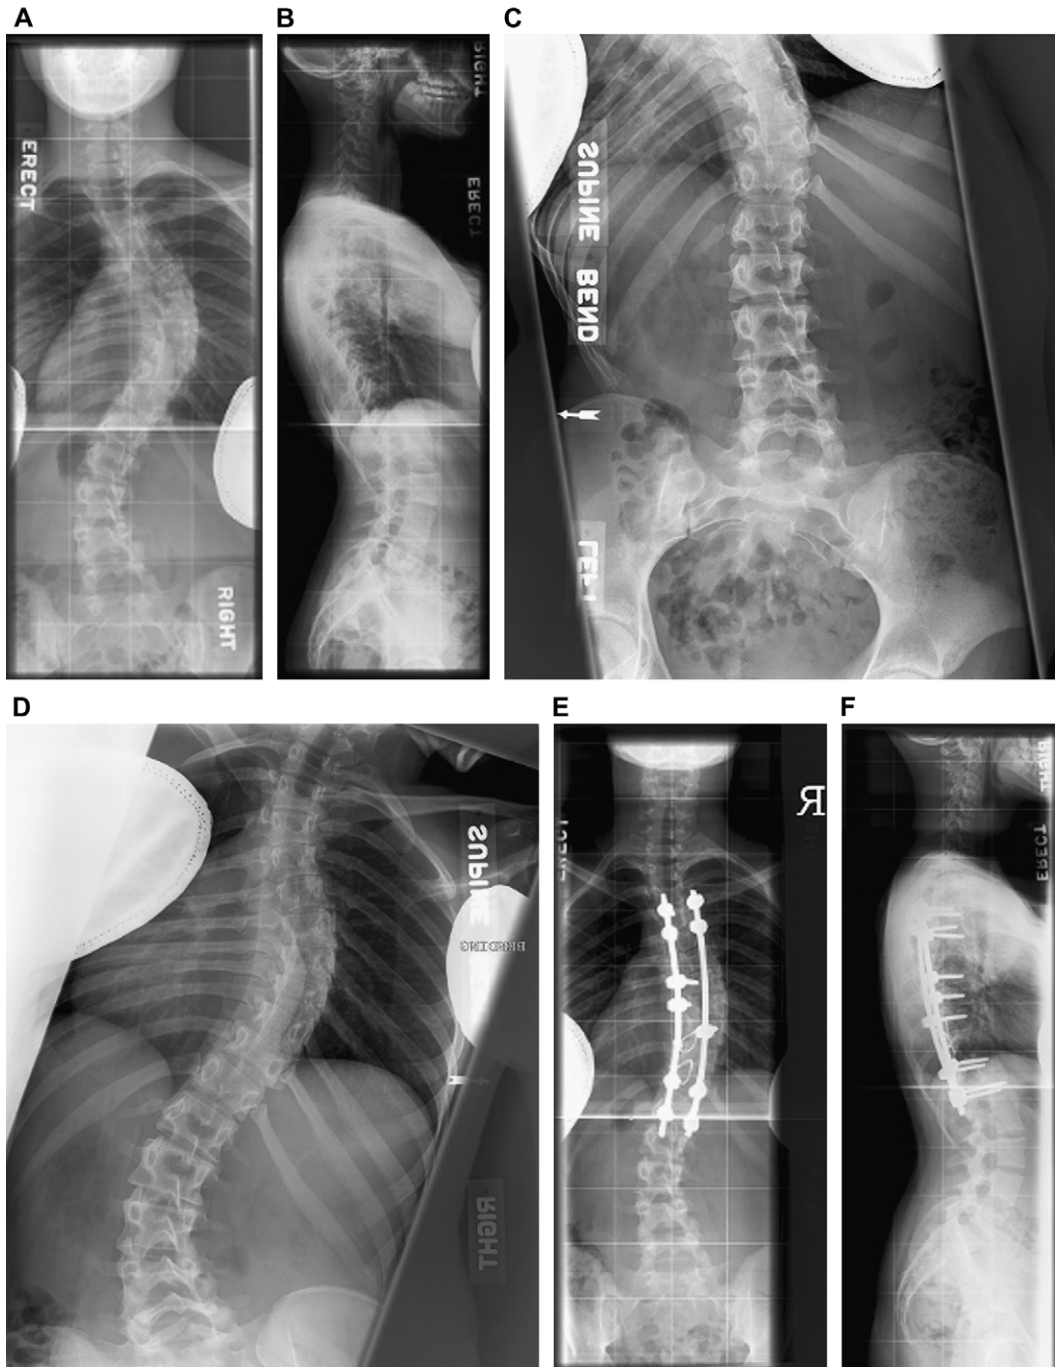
A 17-year-old girl with progressive adolescent idiopathic scoliosis. AP (*A*) and lateral (*B*) views show 36° lumbar and 64.6° thoracic curves that correct on bending films to (*C*) 9.9° and (*D*) 46° . The patient underwent selective thoracic fusion from T4 to T12 with pedicle screws and sublaminar wires; laminotomies were performed at some thoracic levels in order to improve visualization of the pedicles. (*E*, *F*) Postoperative radiographs show a 25° lumbar curve and 32.5° thoracic curve.
